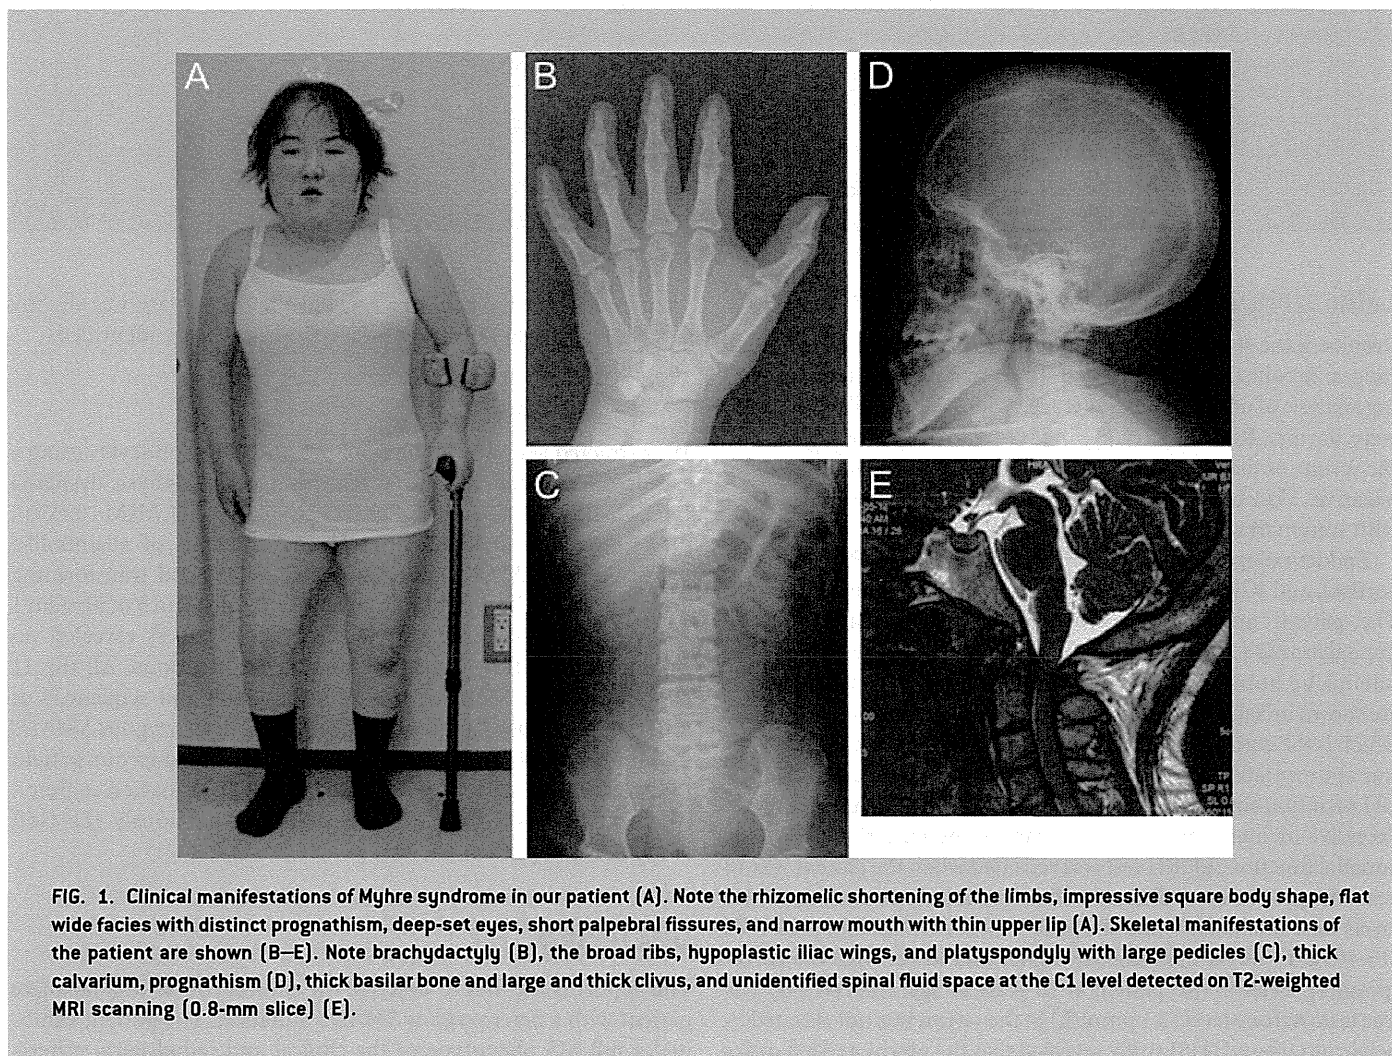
Clinical manifestations of Myhre syndrome in our patient (A). Note the rhizomelic shortening of the limbs, impressive square body shape, flat wide facies with distinct prognathism, deep-set eyes, short palpebral fissures, and narrow mouth with thin upper lip (A). Skeletal manifestations of the patient are shown (B–E). Note brachydactyly (B), the broad ribs, hypoplastic iliac wings, and platyspondyly with large pedicles (C), thick calvarium, prognathism (D), thick basilar bone and large and thick clivus, and unidentified spinal fluid space at the C1 level detected on T2-weighted MRI scanning (0.8-mm slice) (E).
